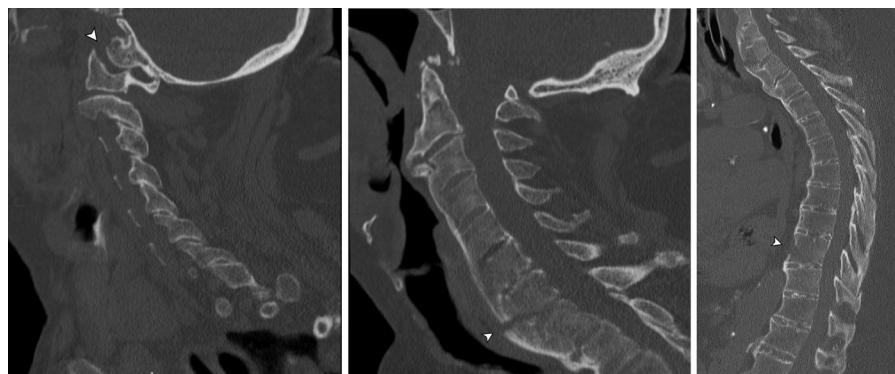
(Left) Sagittal computed tomography of the occipitocervical ligamentous injury, white arrow indicates the widening of the occipitocervical articulation consistent with a ligamentous injury; (Middle) C7–T1 three-column extension injury, white arrow; and (Right) T9–T10 three-column extension fracture, white arrow.
